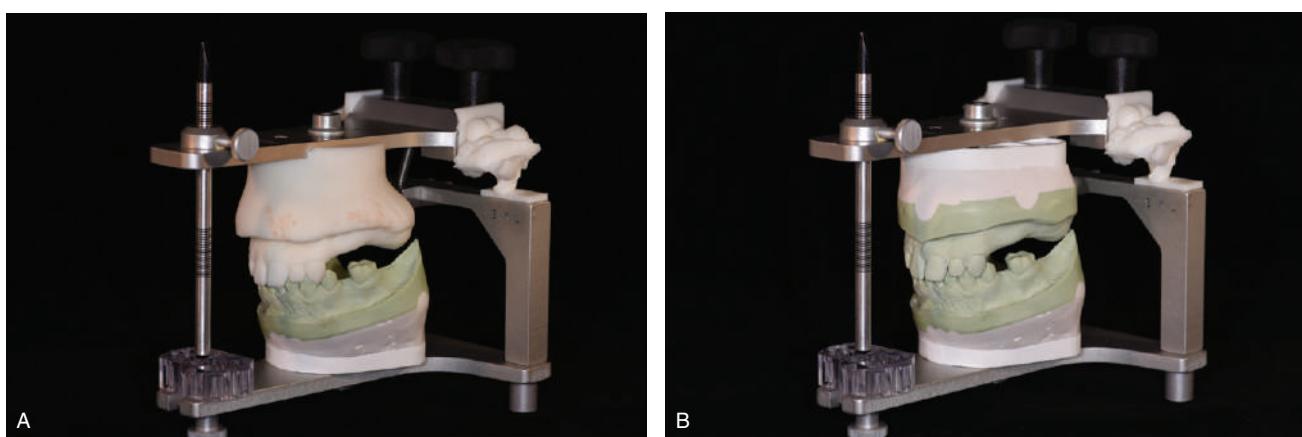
Full assembly of the custom-printed anatomic structures representing the condylar elements, and maxilla related to each other and to the Frankfort horizontal plane from the patient cone-beam computed tomography onto the Whip Mix 8500 series frame. (A) Mandibular cast mounted to the printed maxillary index using traditional centric relation (CR) record, and (B) the maxillary cast is cross-mounted using the same CR record. This patient-specific articulator requires no settings or adjustments. (Courtesy Dr. Shereen S. Azer).
